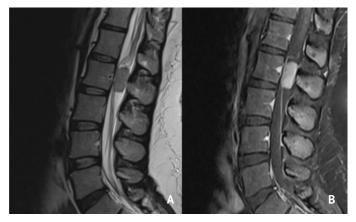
Intradurally located ependymoma at L2 level, MRI sections A) T2-weighted MRI, sagittal section, B) T1-weighted MRI, sagittal section after IV contrast injection MRI: Magnetic resonance imaging, IV: Intravenous
